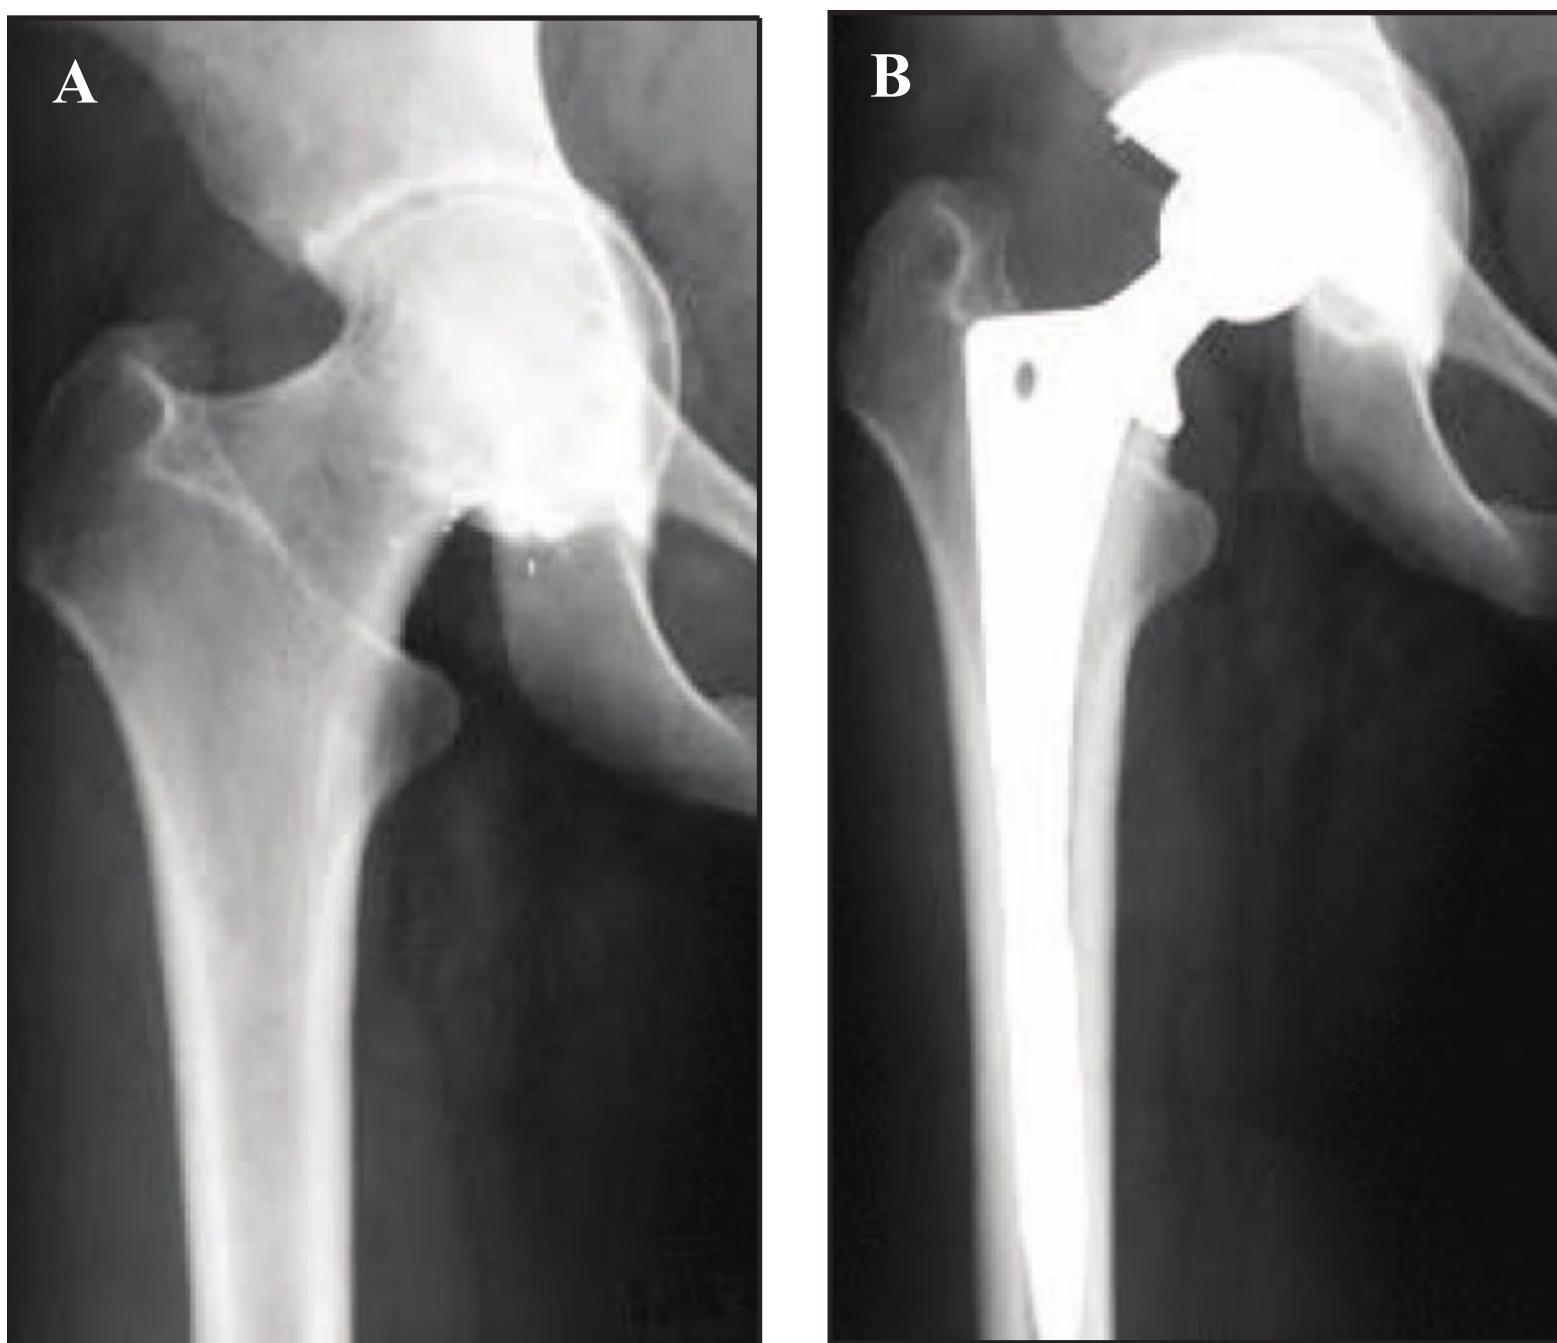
Protrusio is noted on the preoperative x-rays. During the procedure, impaction grafting of reamed femoral head autograft was used to augment the medial wall, and a trabecular metal acetabular component with peripheral rim fit was utilized.
